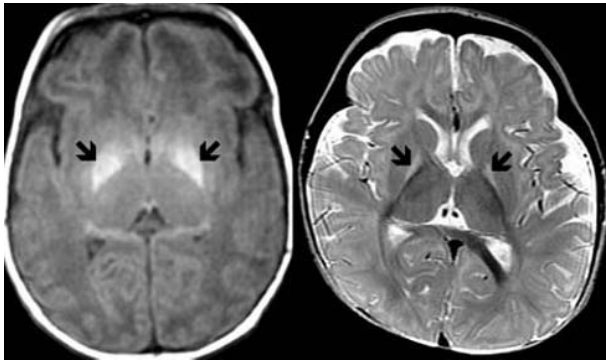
MRI images of a 9-day old infant with acute (left; T1) and an 8-month old infant with chronic (right; T2) bilirubin encephalopathy. The typical findings of bilateral signal change in posteromedial aspect of the globus pallidus (arrows) are present in more than 90% of infants with bilirubin encephalopathy. Courtesy of Dr. A James Barkovich.
